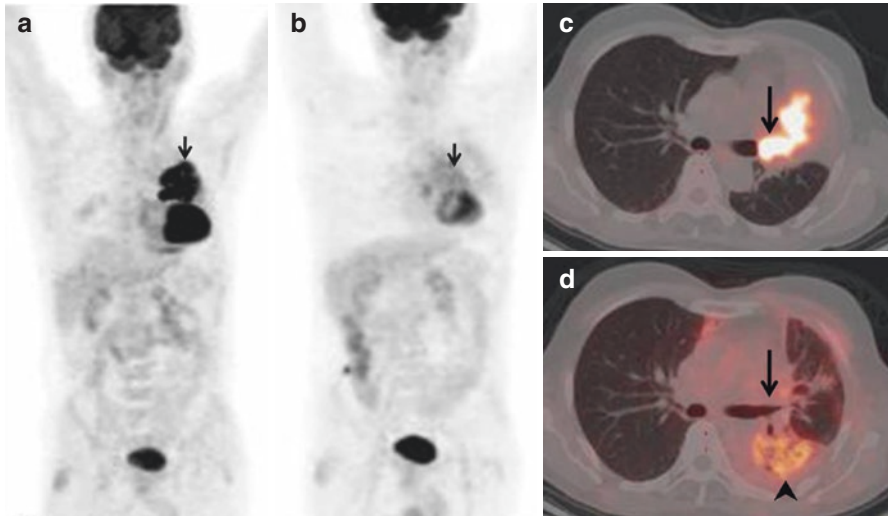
Pretreatment whole body MIP and fusion PET/CT images show a FDG-avid endobronchial soft tissue mass in the left lung (arrows in a, c). PET/CT performed 12 weeks after radiation therapy shows complete metabolic and morphologic regression of the lung mass (arrows in b, d). Note: FDG-avid postradiation pneumonitis (arrow in d) seen distinct from the site of primary mass
